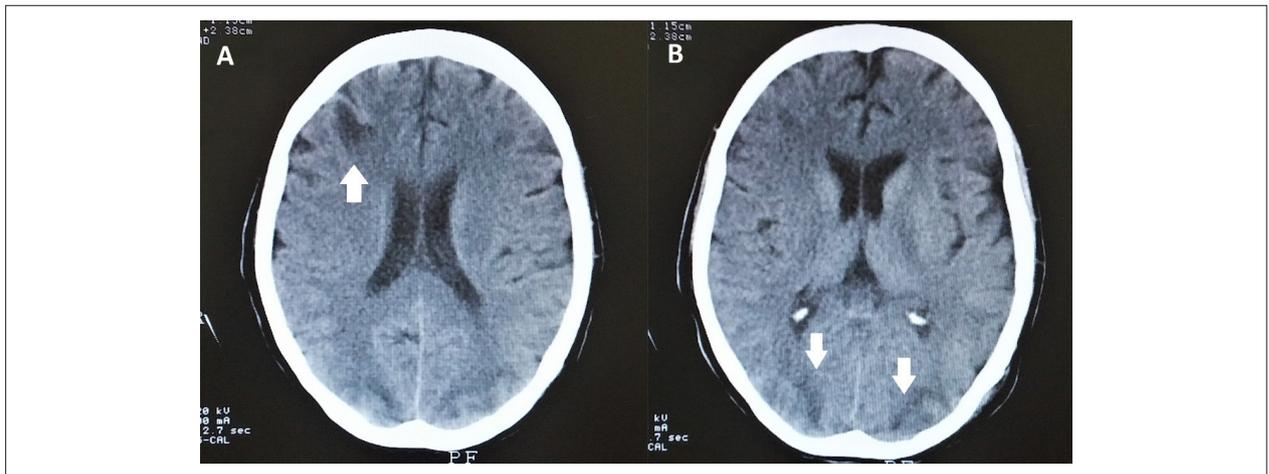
Computed tomography of the brain showing, in both A and B panels, hypodensity areas compatible with lacunar infarcts caused by vasculitis.
